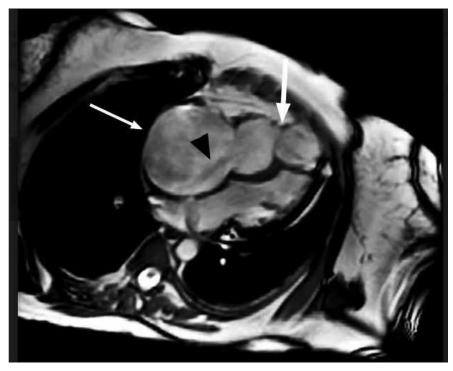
Four-chamber fast imaging employing steady-state acquisition (FIESTA) magnetic resonance image demonstrates an abnormal "waisted" morphology of the right ventricle (*large white arrow*) with irregular trabeculations seen involving the apical portion of the right ventricle. A markedly dilated right atrium is present (*small white arrow*) in addition to a regurgitant jet indicative of tricuspid regurgitation (*black arrowhead*).
